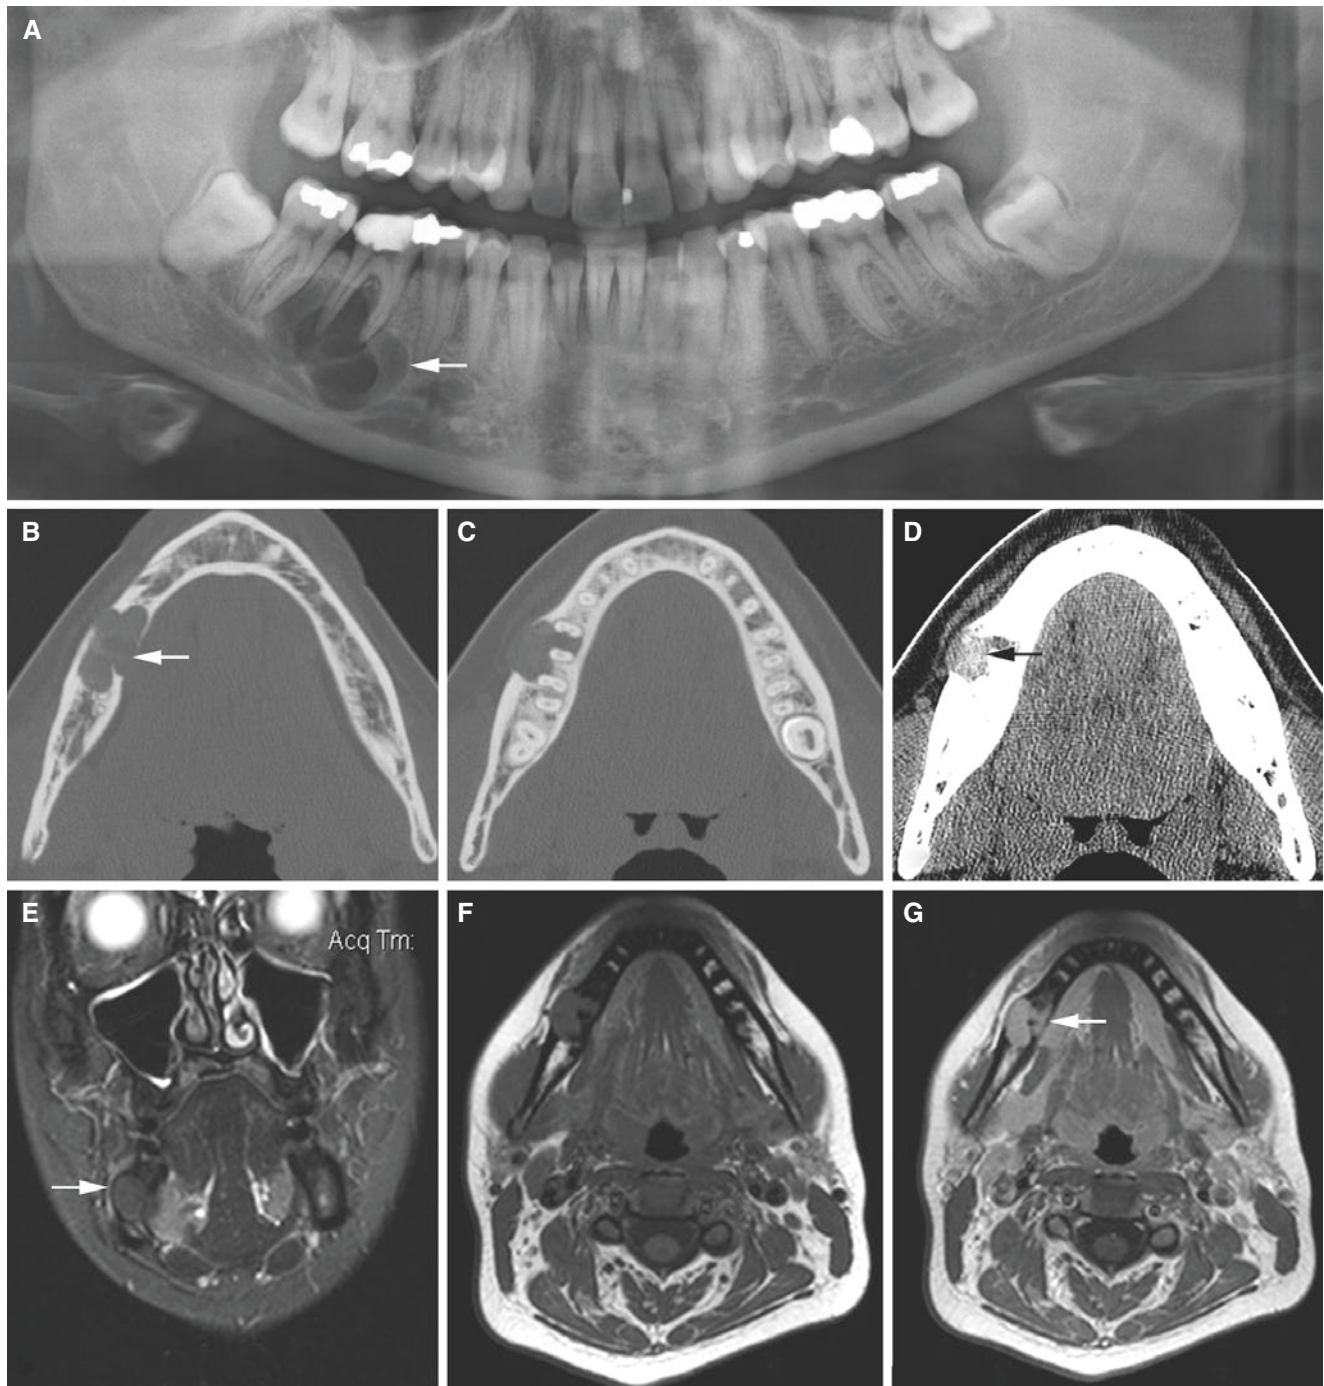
Ossifying fibroma, mandible; 31-year-old female with hard, buccal swelling in the right mandible and variable pain from the first molar (deep filling, vital tooth). (A) Panoramic view shows well-defined multilocular radiolucency in periapical area of the first molar (*arrow*). (B, C) Axial CT images show radiolucency with defects in buccal and lingual cortical plate (*arrow*). (D) Axial (soft-tissue window) CT image shows slight buccal expansion of well-defined
